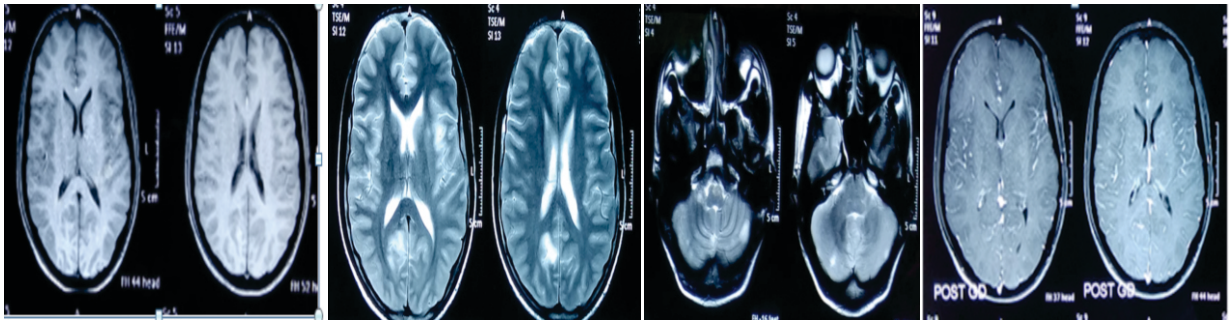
showing MRI brain with T2 hyperintensities involving both cerebral hemispheres and cerebellum with no contrast enhancement.
